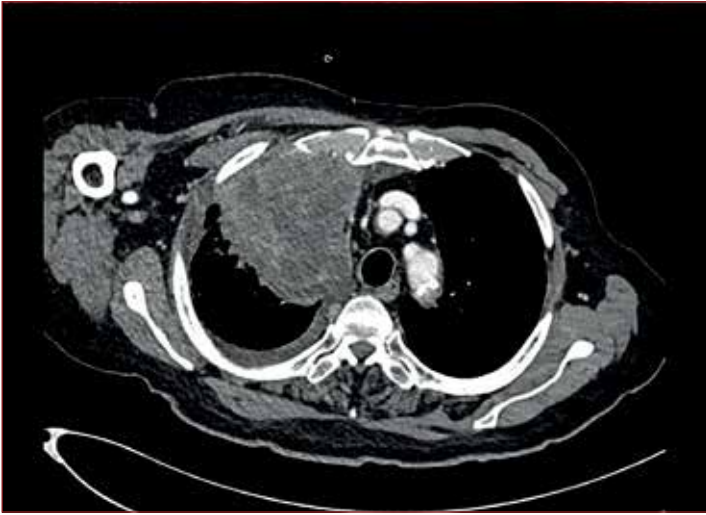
CT-scan with intravenous contrast showing late stage NSCLC with advanced chest wall infiltration.
